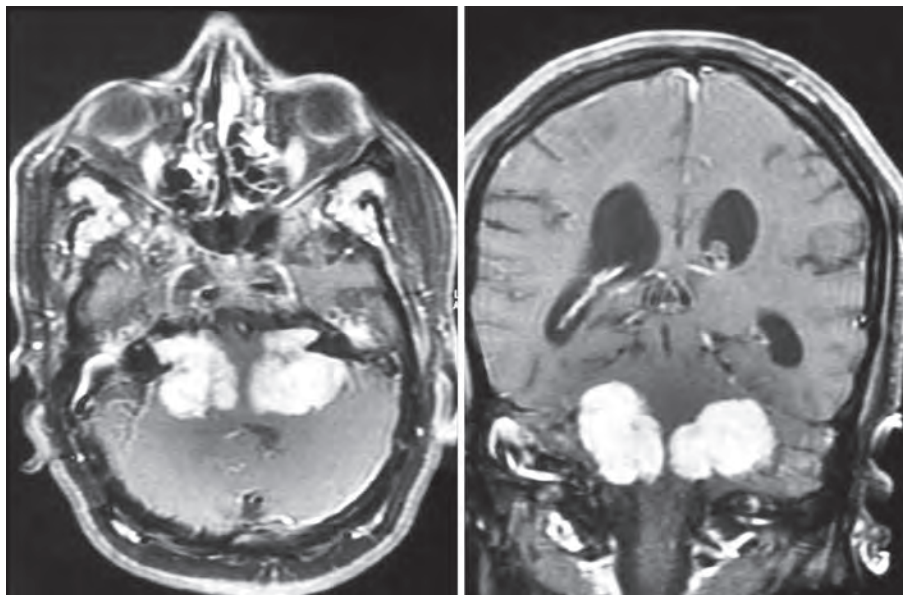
Magnetic resonance imaging scan of brain showing bilateral acoustic schwannomas
